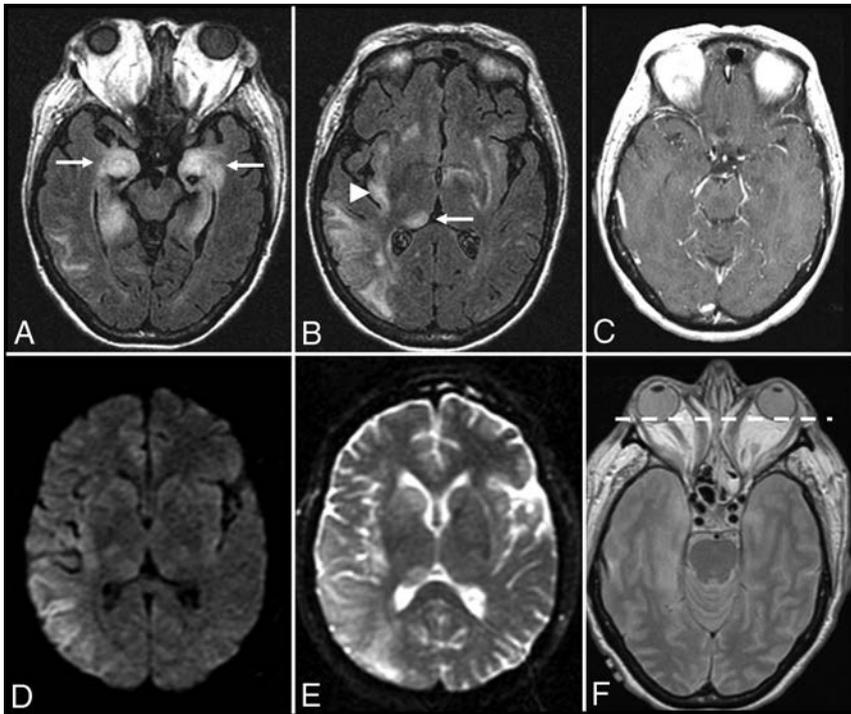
Graves ophthalmopathy with anti-Hu encephalitis. A 63-year-old woman with severe encephalopathy and diffuse enlargement of the extraocular muscles developed fatal autonomic dysfunction. MR imaging of the brain demonstrates prominent T2-FLAIR abnormalities in the mesial temporal lobes (A), right thalamus (B), right > left insular cortex (B), and posterior right temporal lobe (C), without enhancement (C) and with T2 shiethrough but no restricted diffusion on DWI (D) and the corresponding ADC map (E). There is also diffuse symmetric enlargement of the extraocular muscles, resulting in exophthalmos (F).
